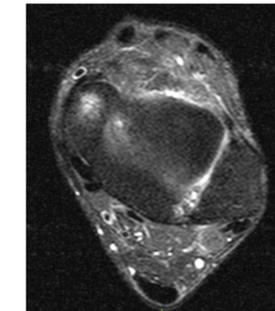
Case 1, 5 years Post-Op MRI: Near complete resolution of tenosynovitis
